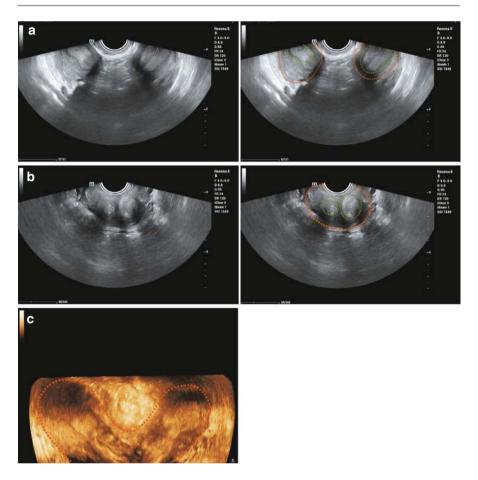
(a) Transverse view of the uterus on ultrasound showing two similarly sized uterine bodies, each exhibiting endometrial echoes at the center. The two uterine bodies are circled in orange, with the endometrial echoes circled in green. (b) Transverse view of the cervix on ultrasound showing a single cervix with double cervical canals. The cervix is circled in orange; the cervical canals are circled in green. (c) Coronal view of the uterus on 3D ultrasound showing both uterine cavities with a tubular pattern
